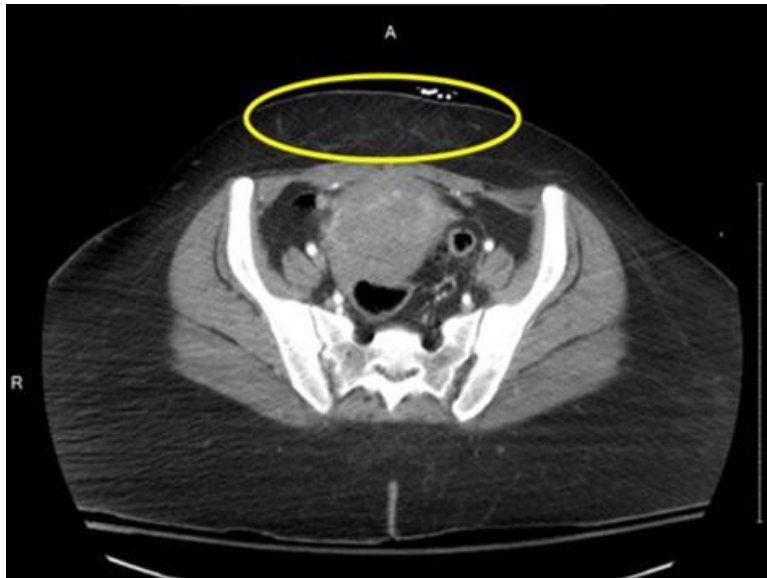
Axial CT at slightly below A.S.I.S level.
